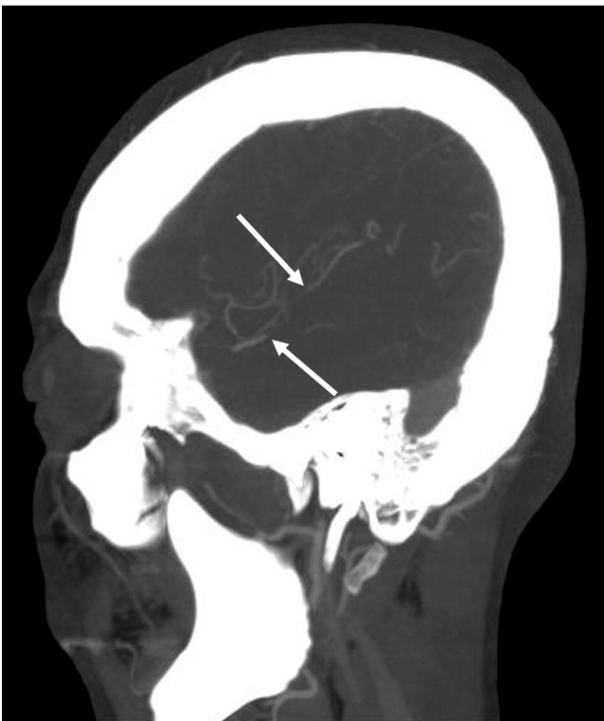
Brain computed tomography angiography with contrast shows a right M2 inferior and superior division branch occlusion (white arrow).
